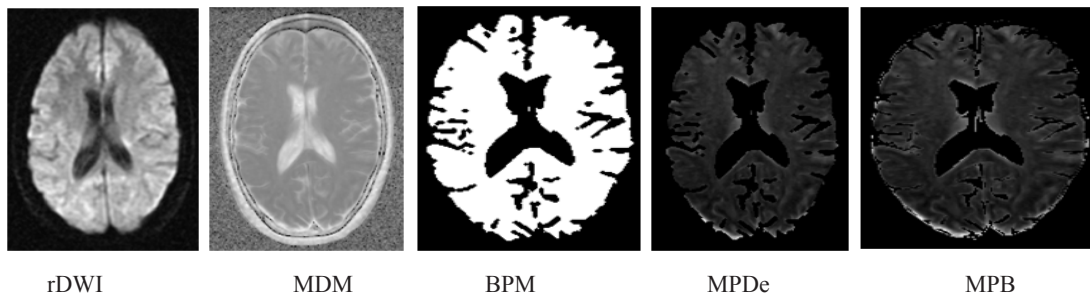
Registration result and mean diffusivity maps. rDWI is registered DWI to T2 image. BPM is applied to MDM to create MPD
